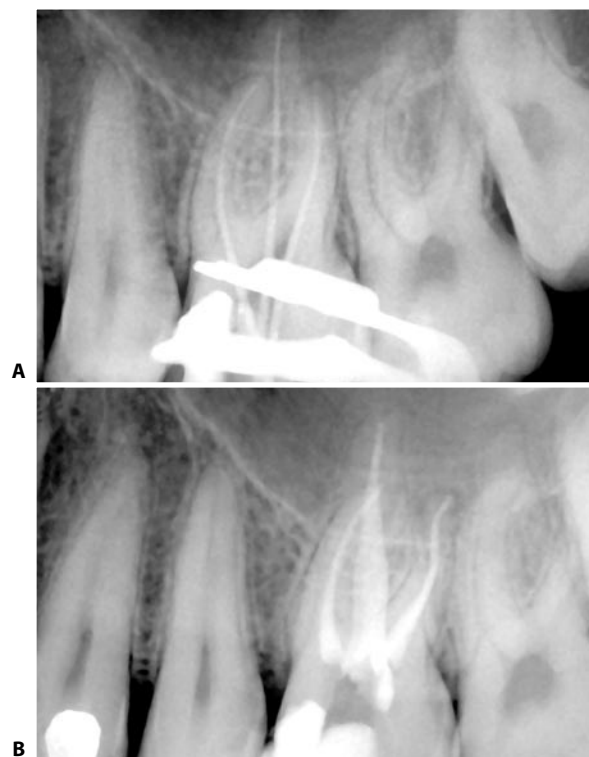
Endodontic treatment of an upper first molar. A. Radiograph of cone fit. Correct positioning at 1 mm from the apex. B. Postoperative radiograph: note the presence of a curvature of the apical third of the disto-buccal canal and the apical control of the obturation in all the canals.
